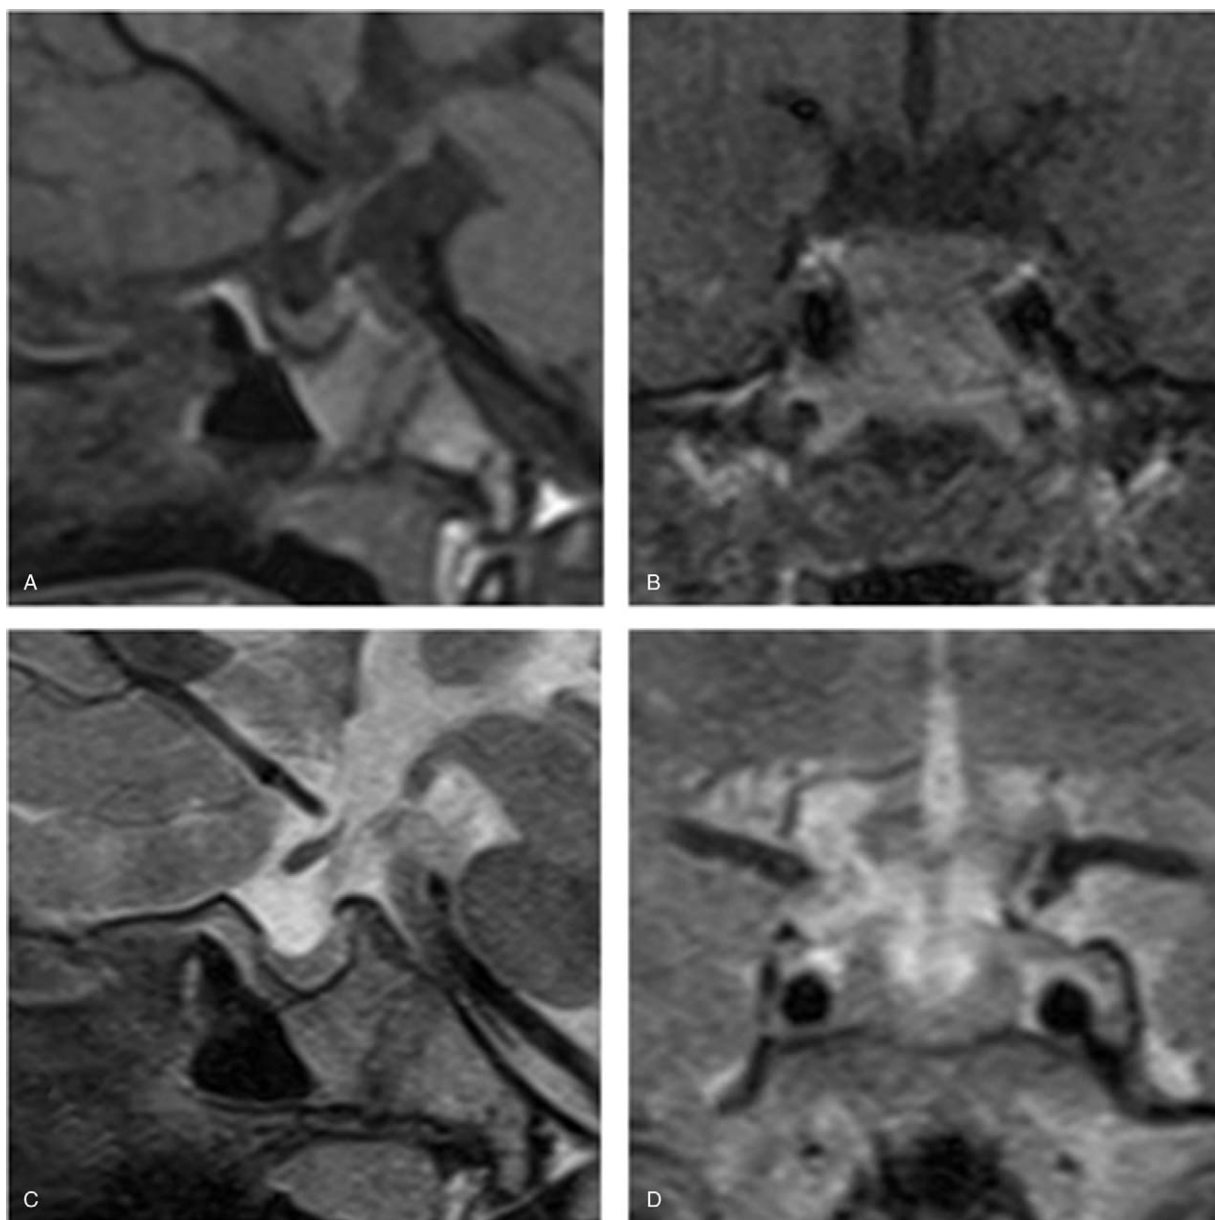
Intracranial MRI of the patient after treatment. A: Sagittal T1WI, uniform signal intensity; B: Coronal T1WI; C: Sagittal T2WI, uniform signal intensity. The mass was reduced in size after treatment, length 3.8mm; D: Coronal T2WI. MRI= magnetic resonance imaging.
